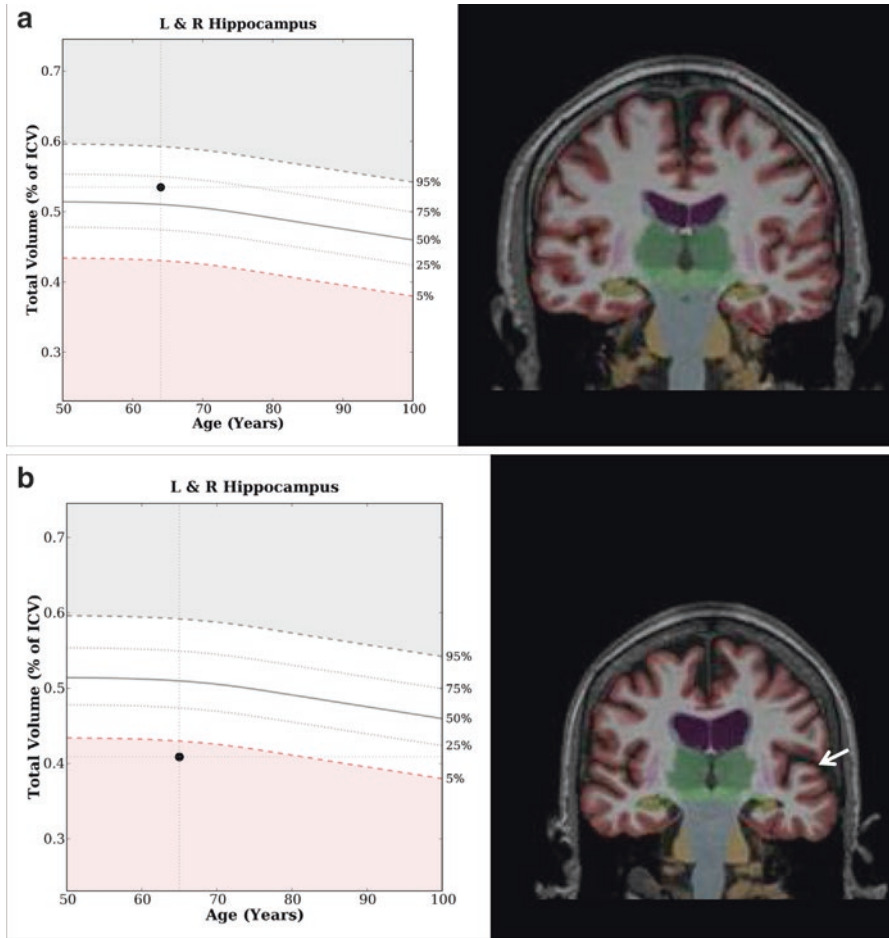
(a) The author’s quantitative imaging based on segmented and classified MRI. The colored region-of-interest map of a coronal section shows the hippocampus highlighted in yellow with the age plot showing above-average volume, adjusted for brain volume. (b) For comparison, this patient has significant deficits in memory and executive functioning and likely a dementing illness. Note that the hippocampal volume is distinctly below the 5th percentile, and as can be seen the white arrow points to a prominent Sylvian fissure, indicative of temporal lobe atrophy, and the hippocampus is visibly smaller than what is observed in (b)
